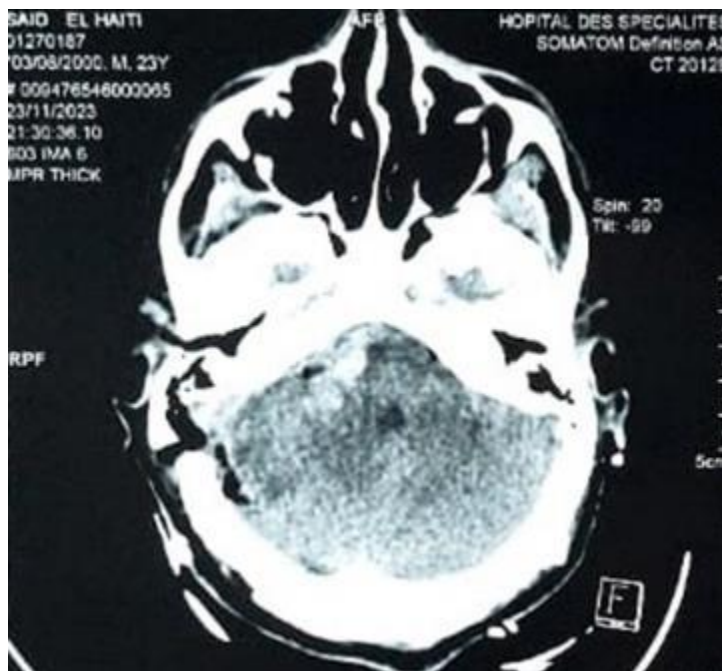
Postoperative head computed tomography scan, axial view, showing complete resection of the tumor
